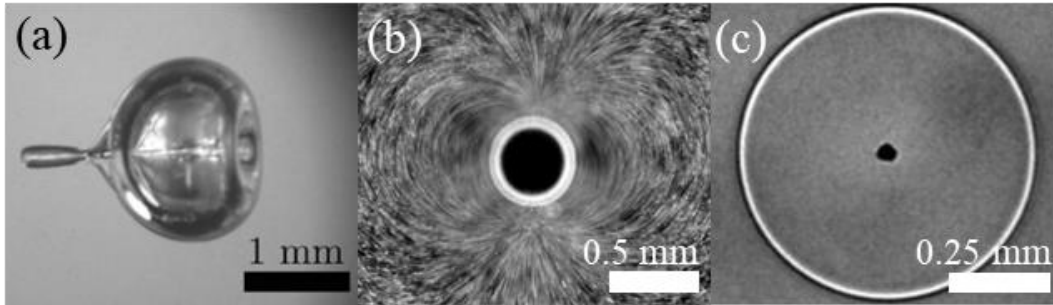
Mechanisms of ultrasonic cavitation damage to bacteria. a) Jetting of bubbles [29]. b) Microstreaming patterns during stable oscillation [30]. c) Shock wave emitted by a collapsing bubble [31].
